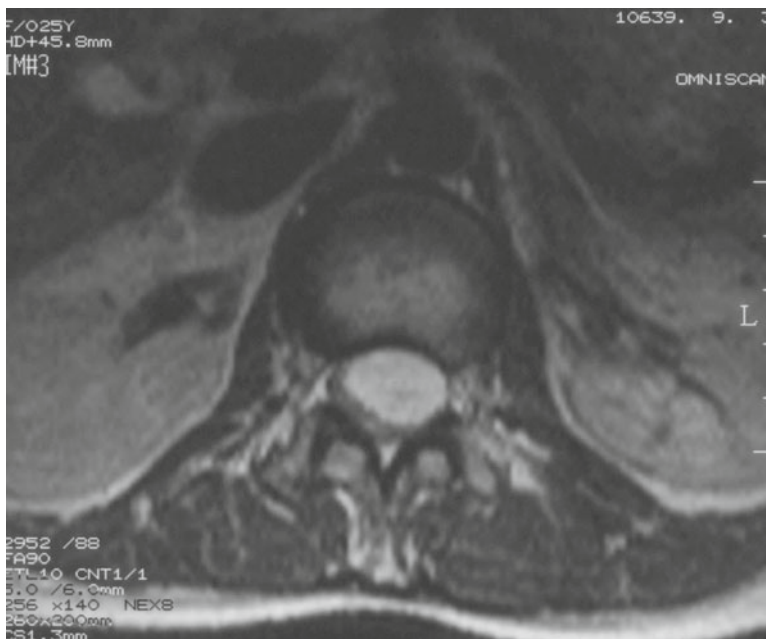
Contrast-enhanced axial T2-weighted image of the lumbar spine showing intradural extramedullary lesion in 26-year-old woman with myxopapillary ependymoma
